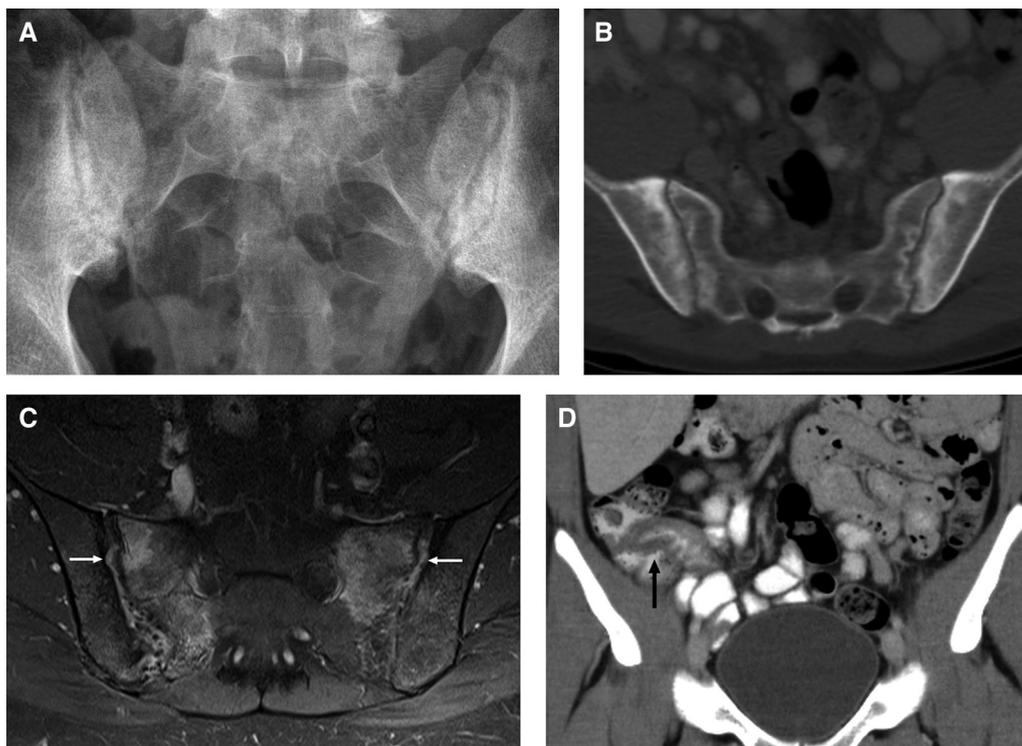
Enteropathy associated sacroiliitis in a patient with Crohn's disease. (A) Radiograph and (B) axial computed tomography shows bilateral sacroiliac joint erosions and subchondral sclerosis. (C) T1-weighted fat saturated postcontrast sequence shows enhancement within both sacroiliac joints and sacral alae (white arrows) consistent with active inflammation. (D) Coronal contrast-enhanced computed tomography abdomen shows circumferential mural thickening of the terminal ileum (black arrow) in keeping with terminal ileitis.
